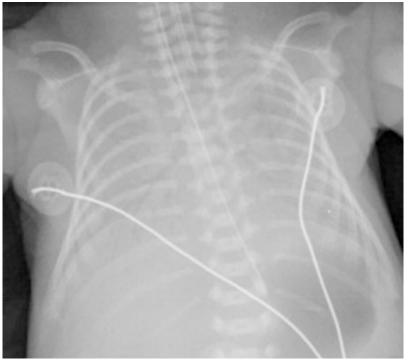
RDS. Frontal chest radiograph performed 24 hours later after endotracheal intubation and surfactant treatment. Lung aeration has improved with mild residual bilateral granular pattern and air bronchograms
